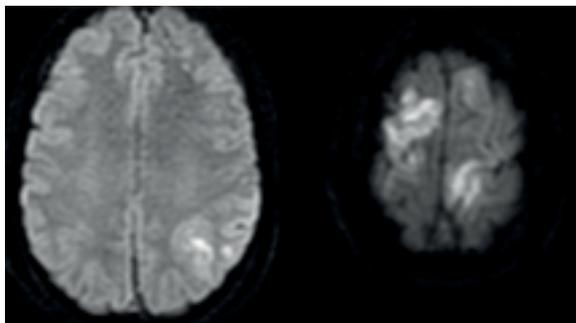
& 14 DWI images: Showing multiple acute infarcts in fronto-parietal region
